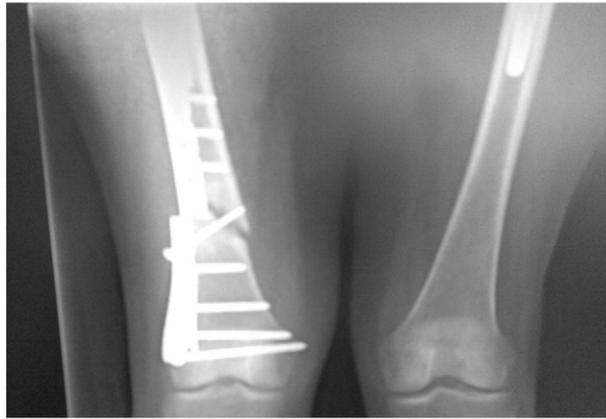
X-ray image showing the bone and the failed supracondylar plate.
